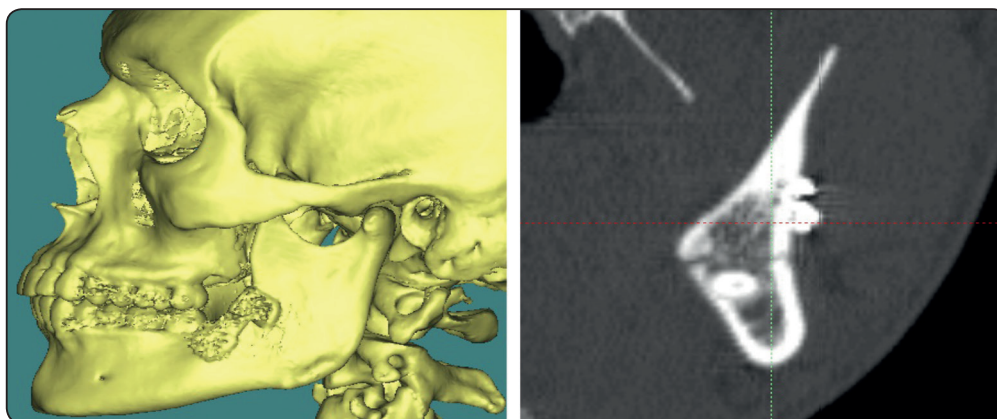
CT images showing the exact alignment of the fractured segments after fixation through the whole mandibular thickness at the fracture line.
